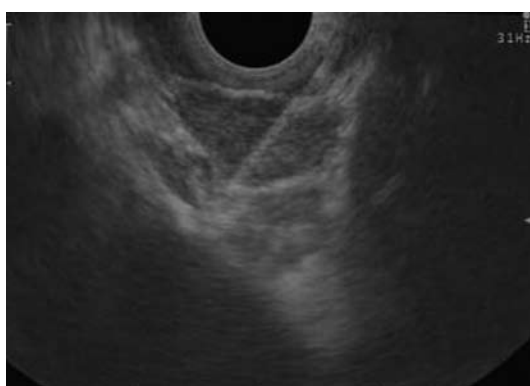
Endoscopic ultrasound-guided fine needle aspiration of lymph nodes in the aortic-pulmonary window in a patient with lung cancer.
